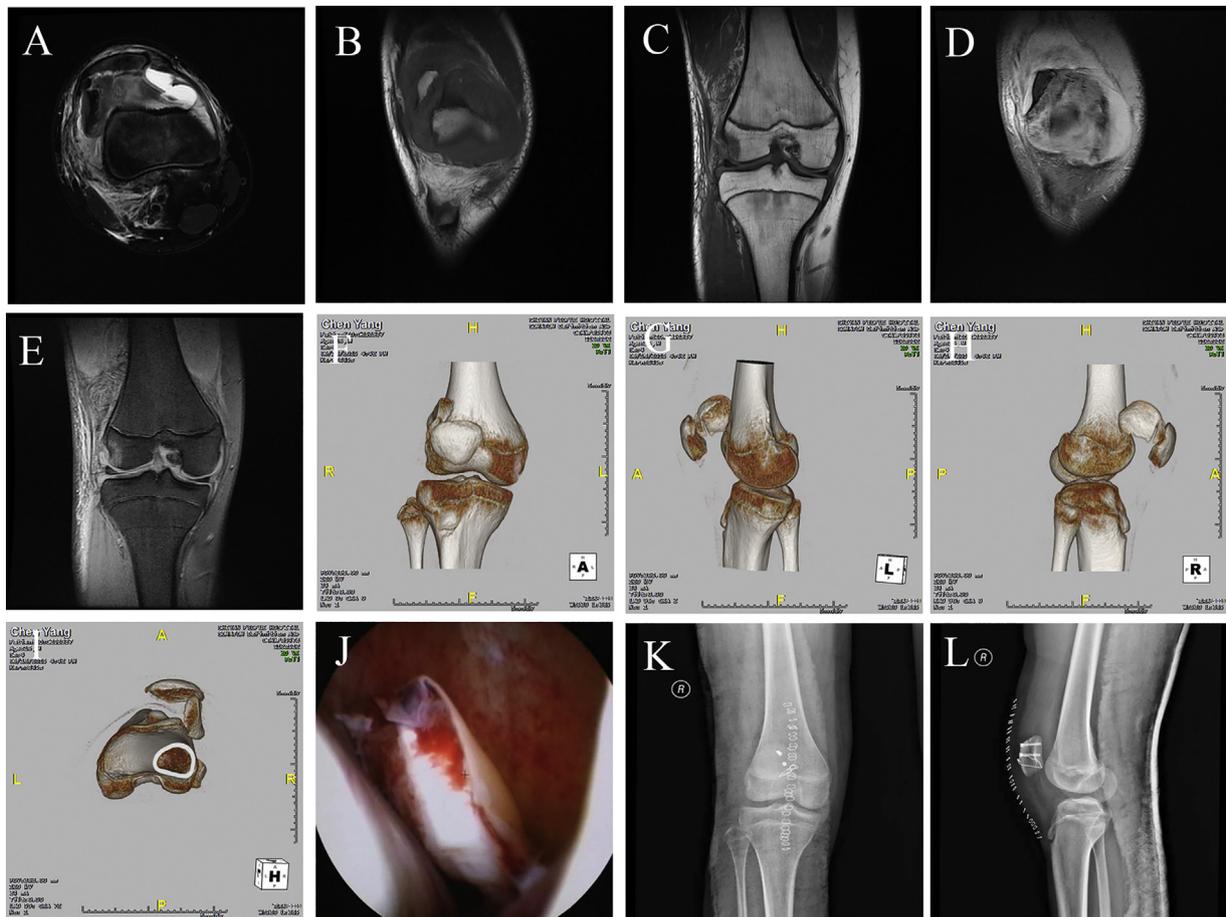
Typical injury patterns associated with Type III MPFL injury are shown. (A) Axial T2 MRI indicates bony fracture occurred from the medial facet of the patella involving articular cartilage. (B) Coronal T1 MRI indicates bony fracture at the medial patellar facet and (C) bone marrow edema at the anterolateral femoral condyle. (D) Coronal T2 MRI indicates bony fracture at the medial patellar facet and (E) bone marrow edema at the anterolateral femoral condyle. (F–I) Computed tomography (CT) reconstruction showed patellar fracture involving the articular cartilage. (J) Arthroscopy was performed initially and an articular fragment of the patella was displayed. (K–L) Besides reconstruction of the MPFL, open reduction and internal fixation were performed along with surgery for the anatomical reduction of the joint surface. On post-surgical anteroposterior and lateral radiographs, cannulated screws, wire and cast are shown.
